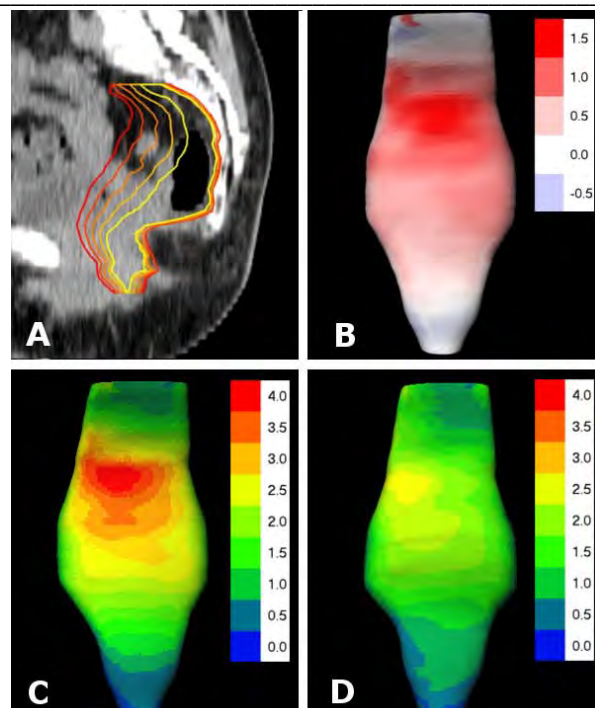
Example of generated LOP structures on a sagittal CT slice (A). Figures B to D depict anterior views of 3D representations of the (average) CTV. Figures C and D present the required margins in the case of bony anatomy based corrections and when using our LoP approach, respectively. Figure B shows the difference between the two methods. All measurements are in cm.
